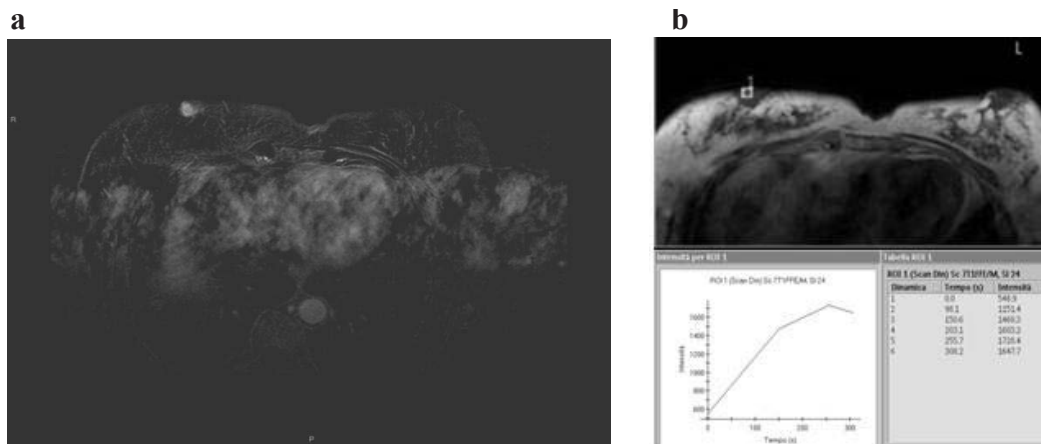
a)* Axial contrast-enhanced fat-suppressed subtraction T1-weighted MR images show asymmetric nodular enhancement in the right nipple. *b)* The time-signal intensity curve appears slow and progressive.
